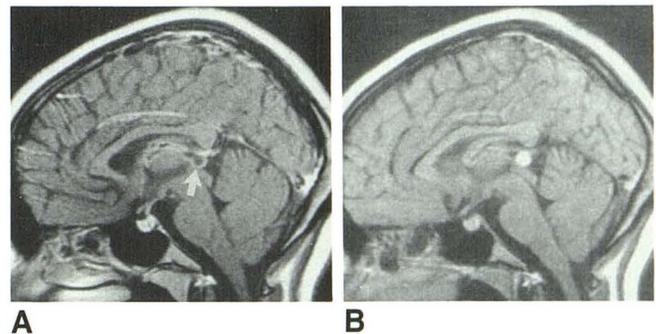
A, MR image obtained immediately after injection of contrast material shows the typical rim enhancement of pineal cyst (arrow). B, On image obtained 1 hr after A, cyst appears uniformly hyperintense.
